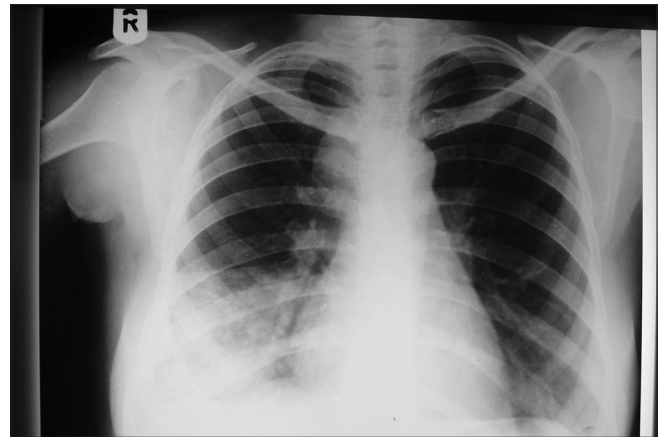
PA chest radiograph of HIV/PTB ARV-naïve patient showing a fairly homogenous opacity in the right lower zone obliterating the adjacent diaphragmatic outline in keeping with consolidation. There is widening of the right superior mediastinum with lobulated outline suggesting mediastinal adenopathy. Right axillary fullness with lobulated outline and curvilinear calcification was also noted suggestive of axillary adenopathy
